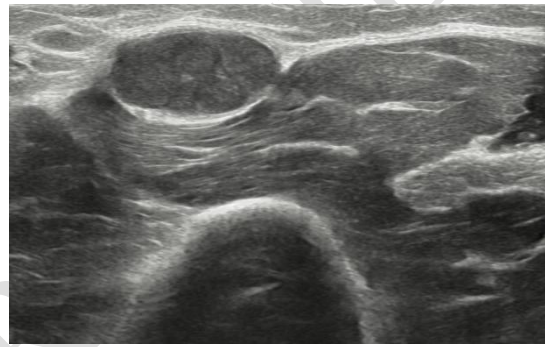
High resolution ultrasound image (transverse view) of normal CPN
